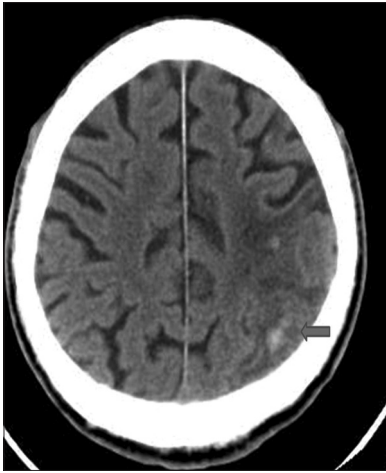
Repeat head computed tomography showing significant resolution of infarct size along with hemorrhagic infarcts in the left parietooccipital region (arrow)
